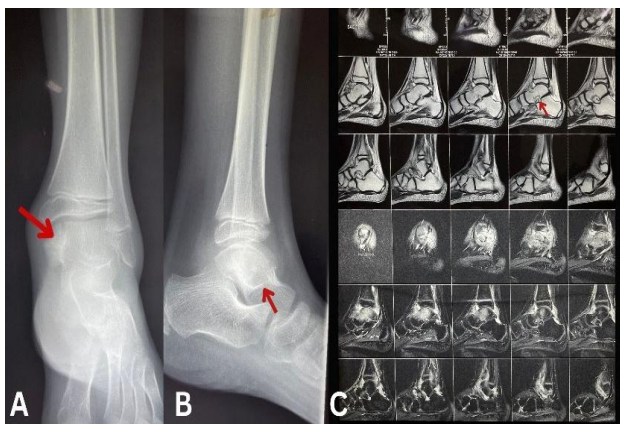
Preoperative imaging of posterior talar osteochondroma. (A) Anteroposterior radiograph of the ankle demonstrating a well-defined bony outgrowth arising from the posterior aspect of the talus (arrow). (B) Lateral radiograph showing a pedunculated osseous projection from the posterior talar process (arrow). (C) Magnetic resonance imaging of the ankle (sagittal sections) revealing a lesion arising from the posterior talus with continuity of the cortical and medullary bone with the parent talus (arrow), consistent with osteochondroma.
